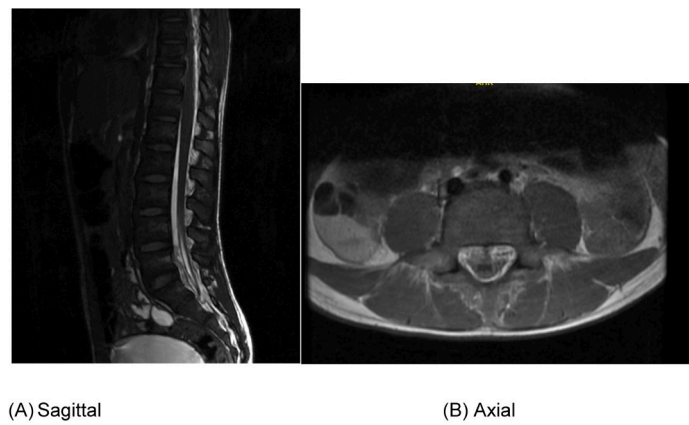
Sagittal and axial spine magnetic resonance imaging showing thickening and enhancement of the nerve roots of the conus medullaris, cauda equina, exiting nerve roots exiting from L5 to S2.
